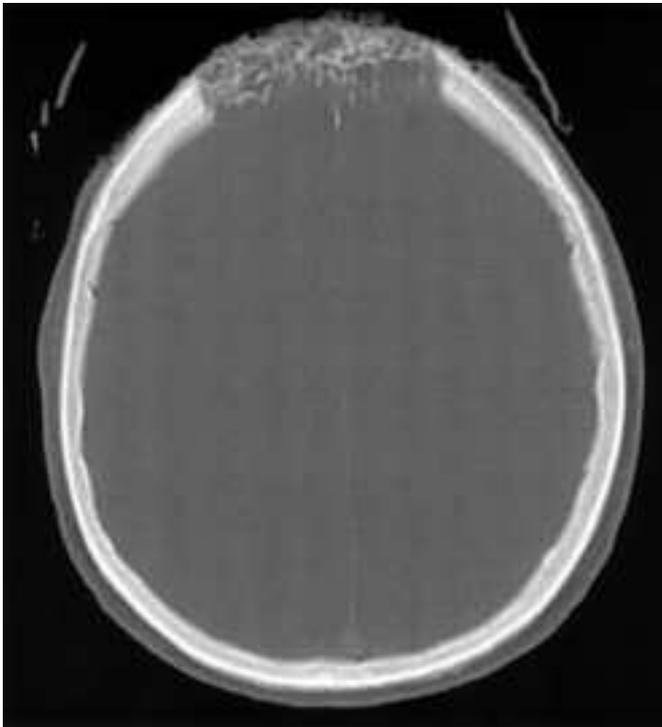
Head CT scan with bone windows. Invasion and destruction of the frontal bone is demonstrated bilaterally.
